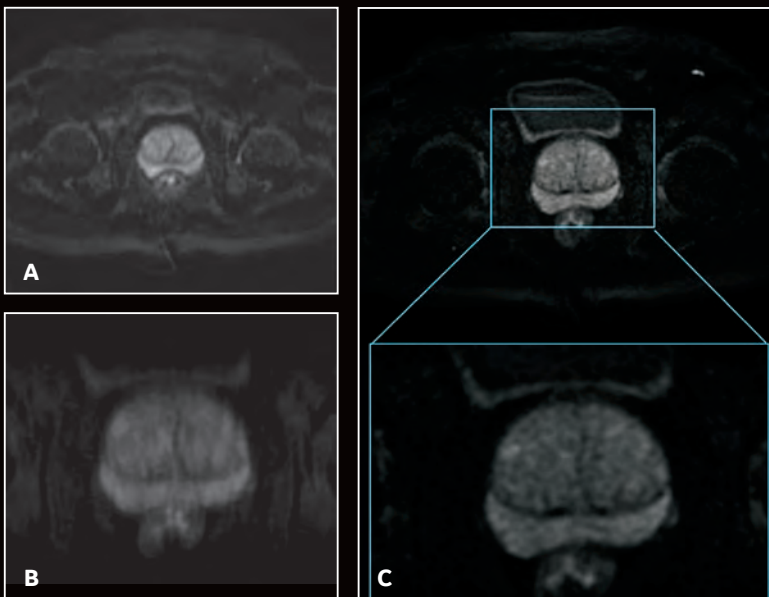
Patient referred for prostate exam. (A) DWI b1000, 2.3 x 2.3 x 4 mm, 2:08 min.; (B) FOCUS b1000, 1.5 x 1.8 x 4 mm, 4:10 min.; and (C) MUSE 3 shot b1000, 1.6 x 1.6 x 4 mm, 4:15 min.
